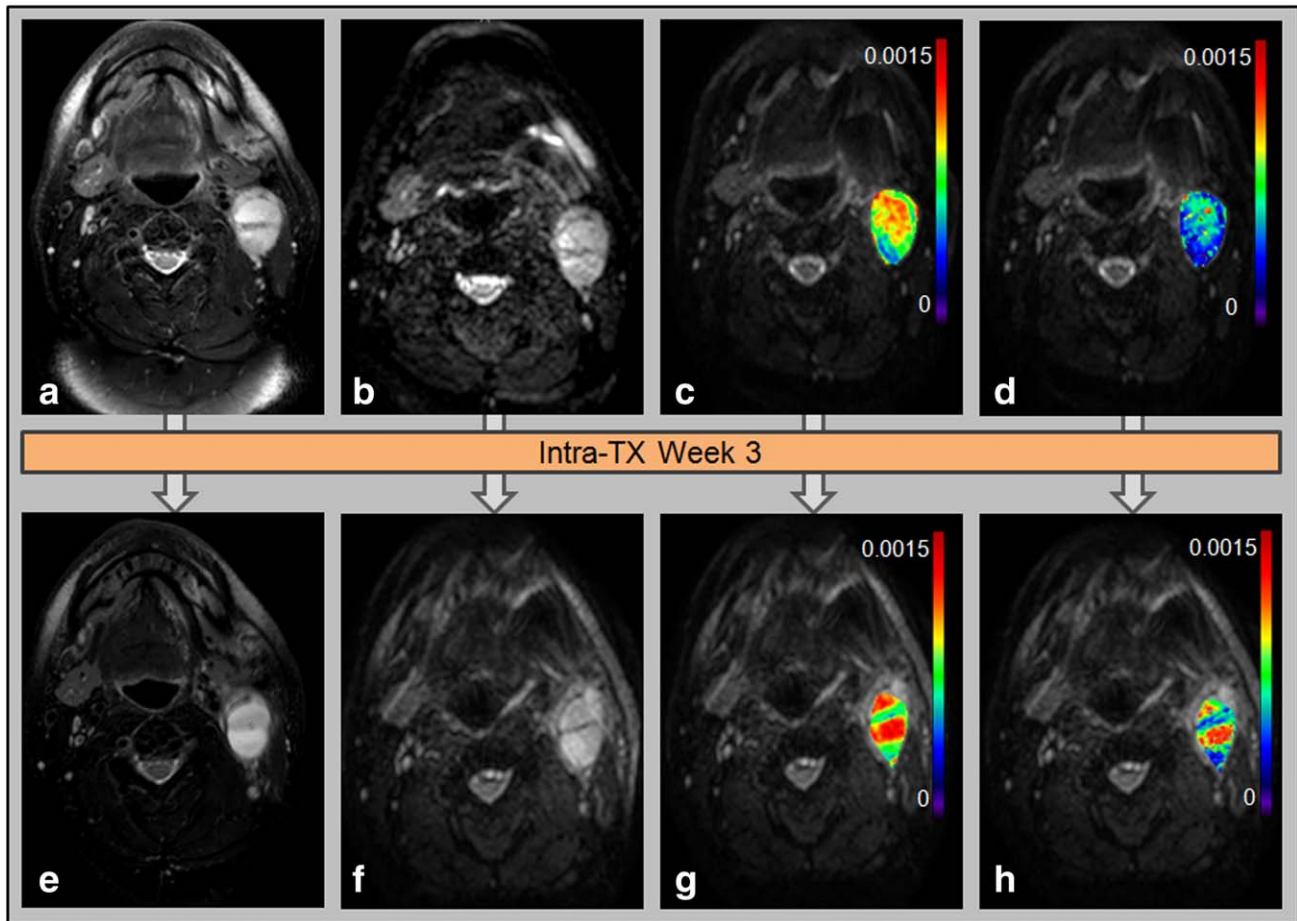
Representative pre-TX (top) and intra-TX week 3 (bottom) MR images of a patient who showed CR (52 years, male). T2-weighted images (a,e). Diffusion-weighted ($b = 0$ s/mm²) images (b,f). ADC (mm²/s) (c,g) and D (mm²/s) (d,h) map overlaid on DW ($b = 0$ s/mm²) images.
